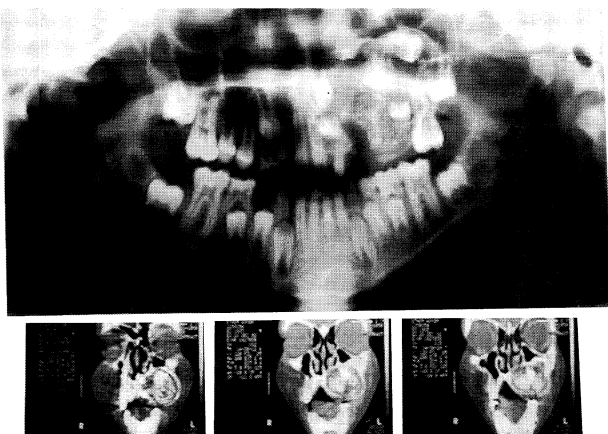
Preoperative panoramic radiography and computerized tomography views of the affected site.
